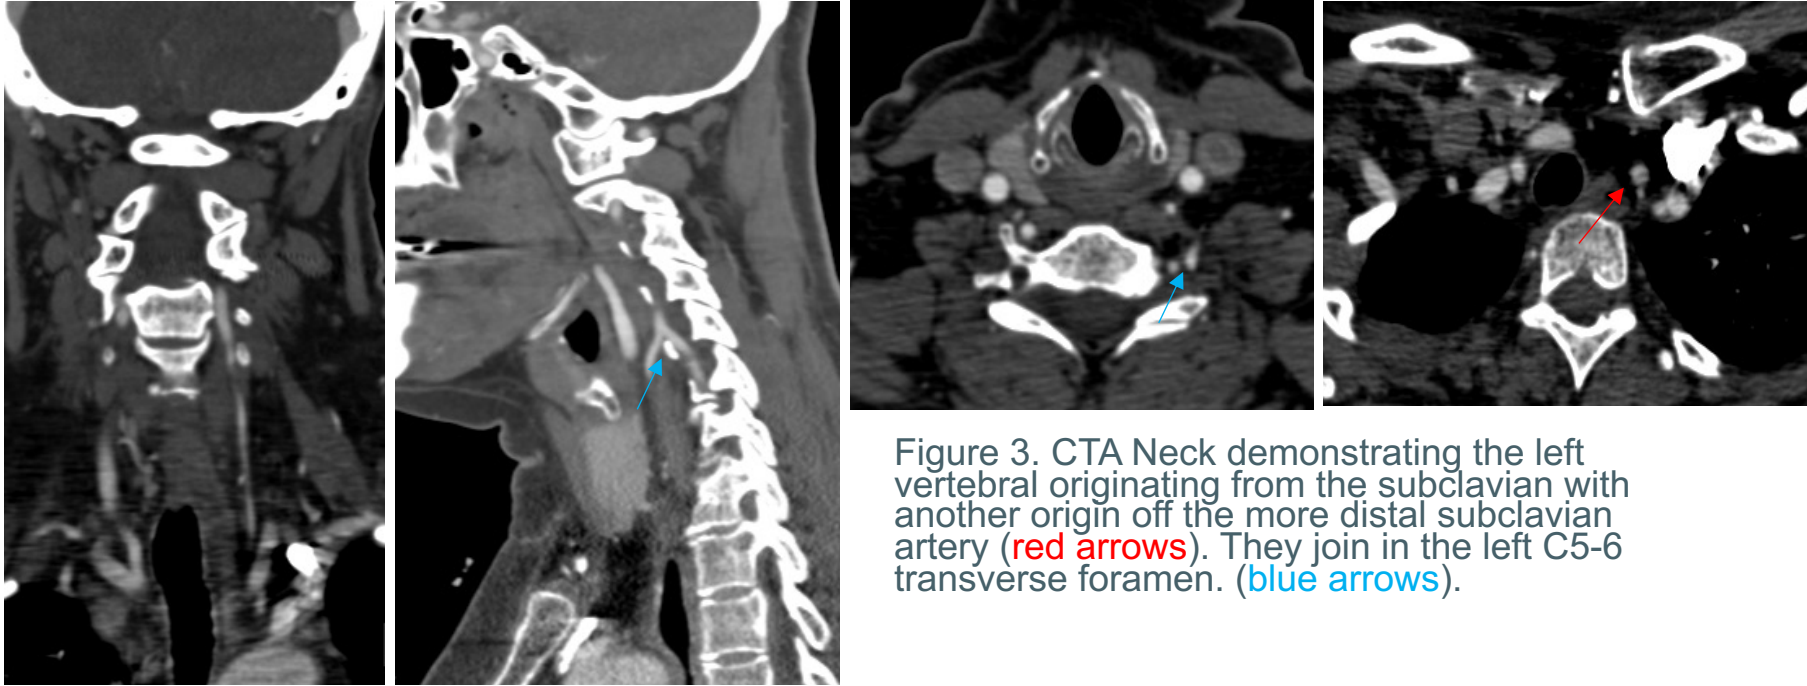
CTA Neck demonstrating the left vertebral originating from the subclavian with another origin off the more distal subclavian artery (red arrows). They join in the left C5-6 transverse foramen. (blue arrows).
